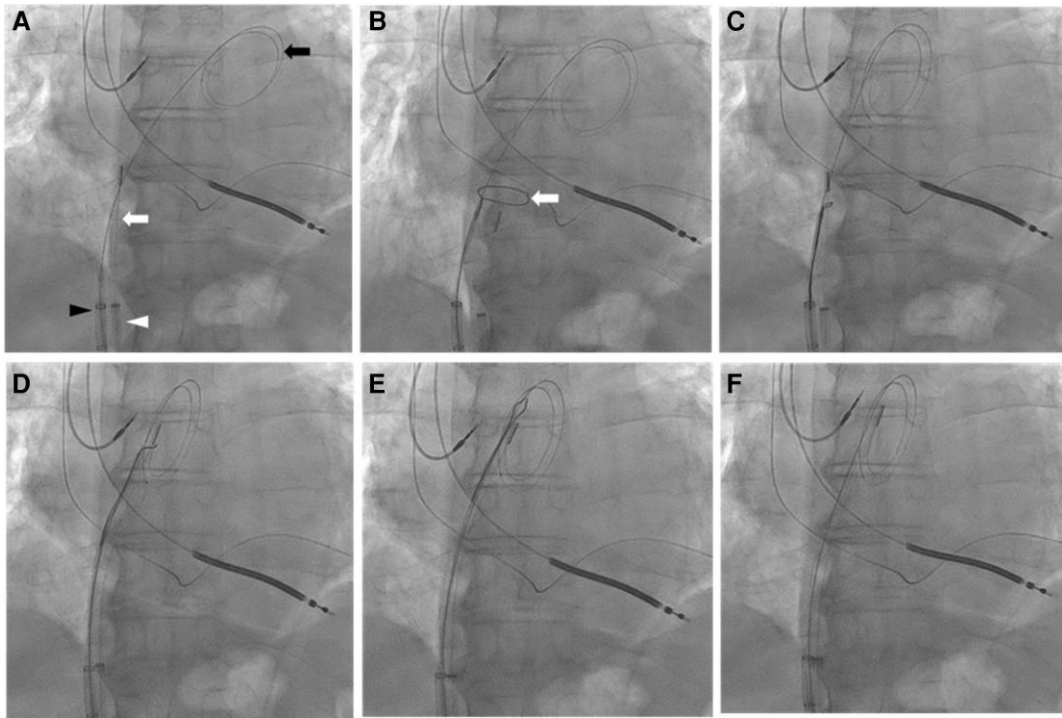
(A) ProTrack wire in the left atrium (black arrow), 10 French intracardiac echocardiogram catheter in the right atrium (white arrow), 16 French Performer Check-Flo introducer (black arrow head), and 10 French Flexor Check-Flo introducer (white arrow head). (B) 25 mm ev3 GooseNeck snare (white arrow) deployed prior to grasping the tip of intracardiac echocardiogram catheter. (C) Intracardiac echocardiogram catheter was grasped and brought closer to the multipurpose guide and ProTrack Wire. (D) Intracardiac echocardiogram catheter was advanced with the multipurpose guide into the left atrium. (E) Releasing the tip of intracardiac echocardiogram catheter. (F) ev3 GooseNeck snare and multipurpose guide were removed.
